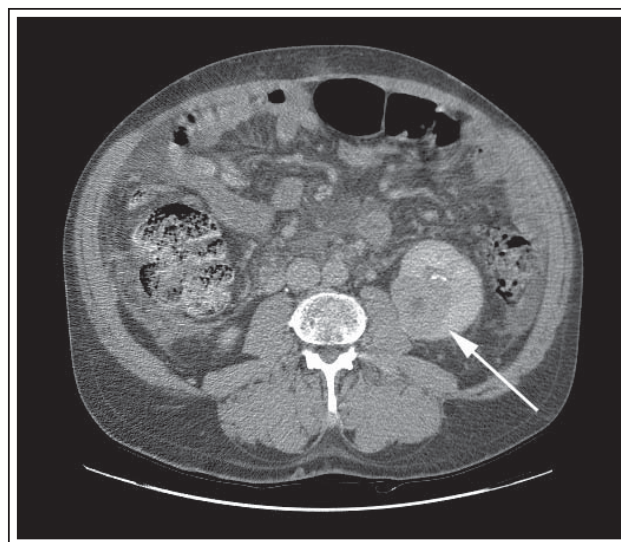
Contrast CT of abdomen and pelvis showing 4.0 cm left lower-pole renal mass.
